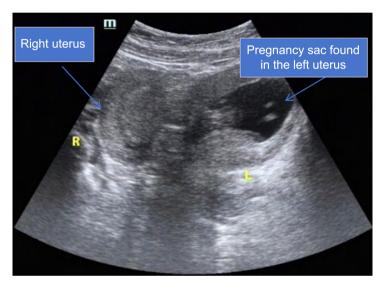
Two-dimensional ultrasound showing two uteruses and Pregnancy sac found in the left uterus.
